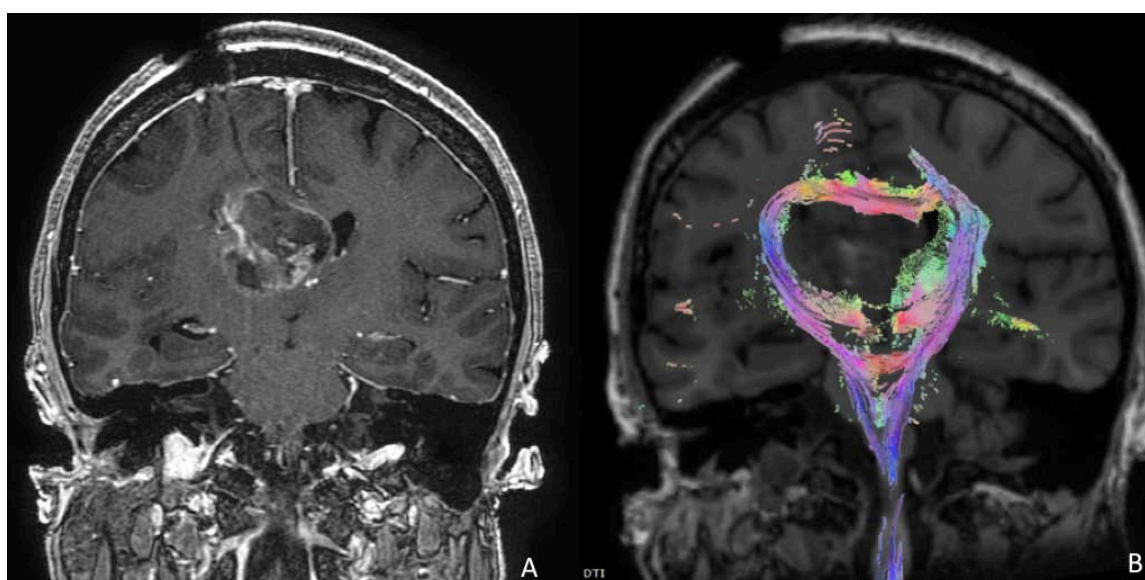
GBM affect on motor tracts. If no language mapping is required, both cortical and subcortical motor mapping may be performed with the patient asleep with good results for both EOR and neurological functional preservation Representation of a right frontal GBM shown on gadolinium enhanced MRI (a) with DTI-FT sequencing showing significant displacement and interruption of descending motor fibers (b). DTI-FT, DTI with fiber tracking; EOR, extent of resection; GBM, glioblastoma multiforme; MRI, magnetic resonance imaging.
